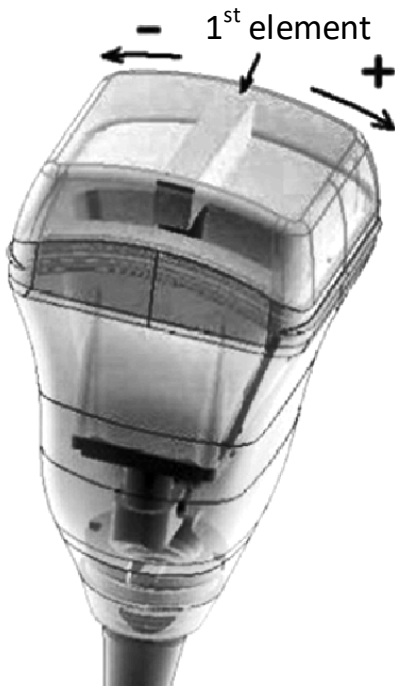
Custom three-dimensional (3D) ultrasound (US) imaging transducer that contains a 192-element linear array that is mechanically scanned over a volume of interest.
